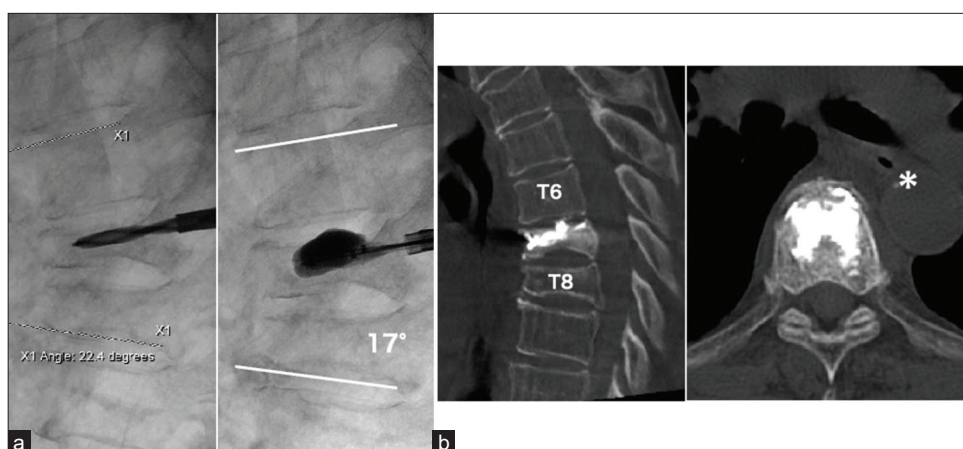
(a) Intraoperative balloon kyphoplasty (BKP) findings were correctable from 22.4 to 17 degrees. (b) Thoracic spine computed tomography after BKP surgery showed intraesophageal air (asterisk) was also confirmed.
